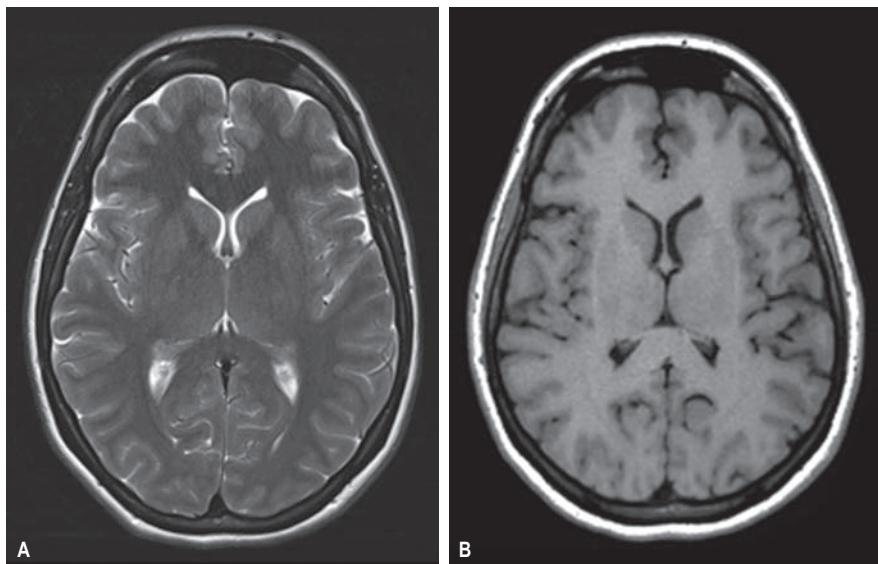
(A) T2-weighted magnetic resonance image of the brain where water is bright and pathology involving oedema is best demonstrated. (B) T1-weighted magnetic resonance imaging where water is black and anatomic features are well demonstrated, maximizing soft tissue contrast.
